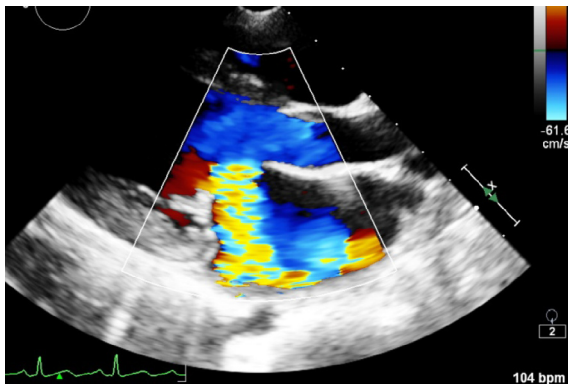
Figure A 2D TTE long axis view with color Doppler showing a severe eccentric regurgitant flow through the anterior mitral leaflet. The regurgitant flow is directed toward the left atrial posterior wall.
